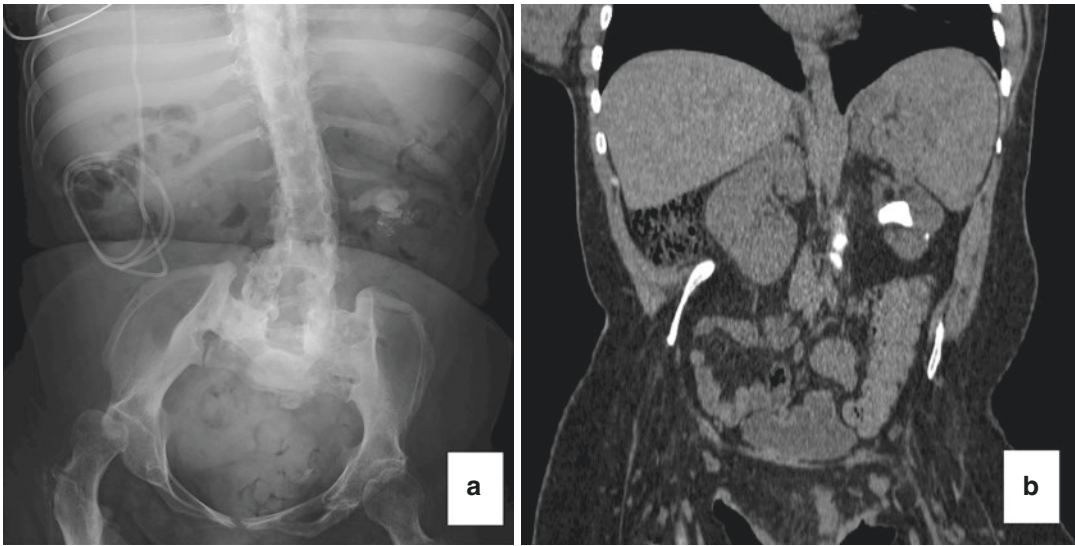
Images from a 41-year old patient with spina bifida presenting with a left incomplete staghorn lithiasis measuring 24 × 13 mm. (a) Plain abdominal X-Ray. (b) CT scan
